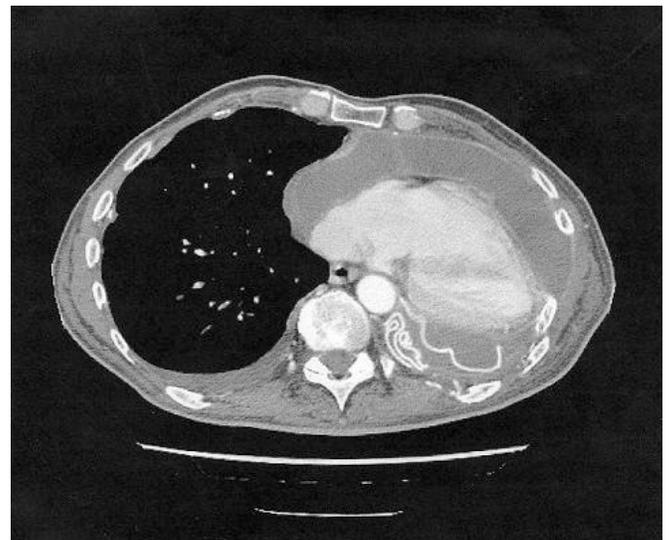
CT scan of the same patient showing posterolateral prosthetic packing.
